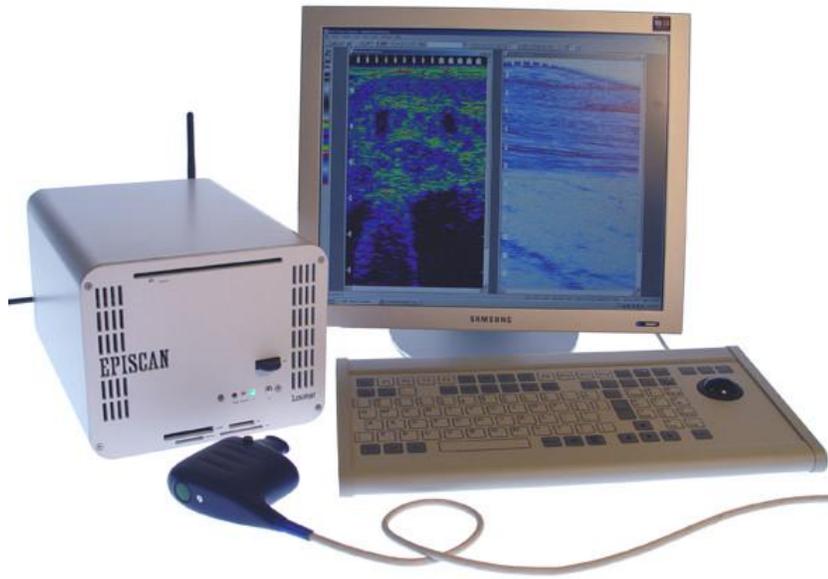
High Frequency Diagnostic Ultrasound Scanner
